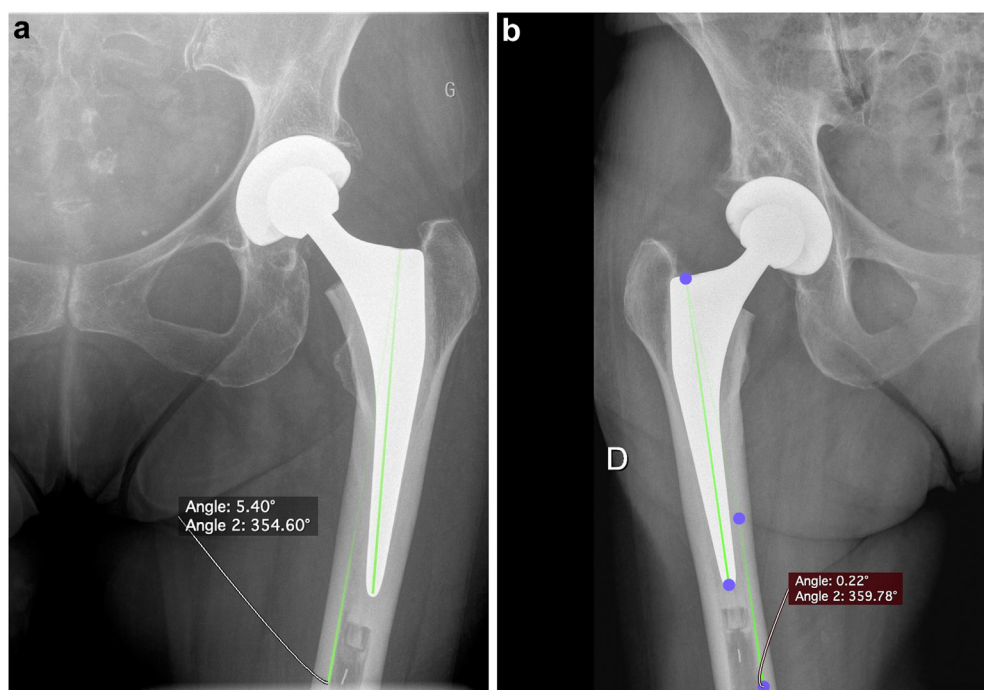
(a). Immediate postoperative right anteroposterior hip radiographs with the stem in the neutral position (Khalily angle: 0.22°) and (b) immediate postoperative left anteroposterior hip radiographs with the stem in the varus position (Khalily angle: 5.40°). D, Droit (right).
